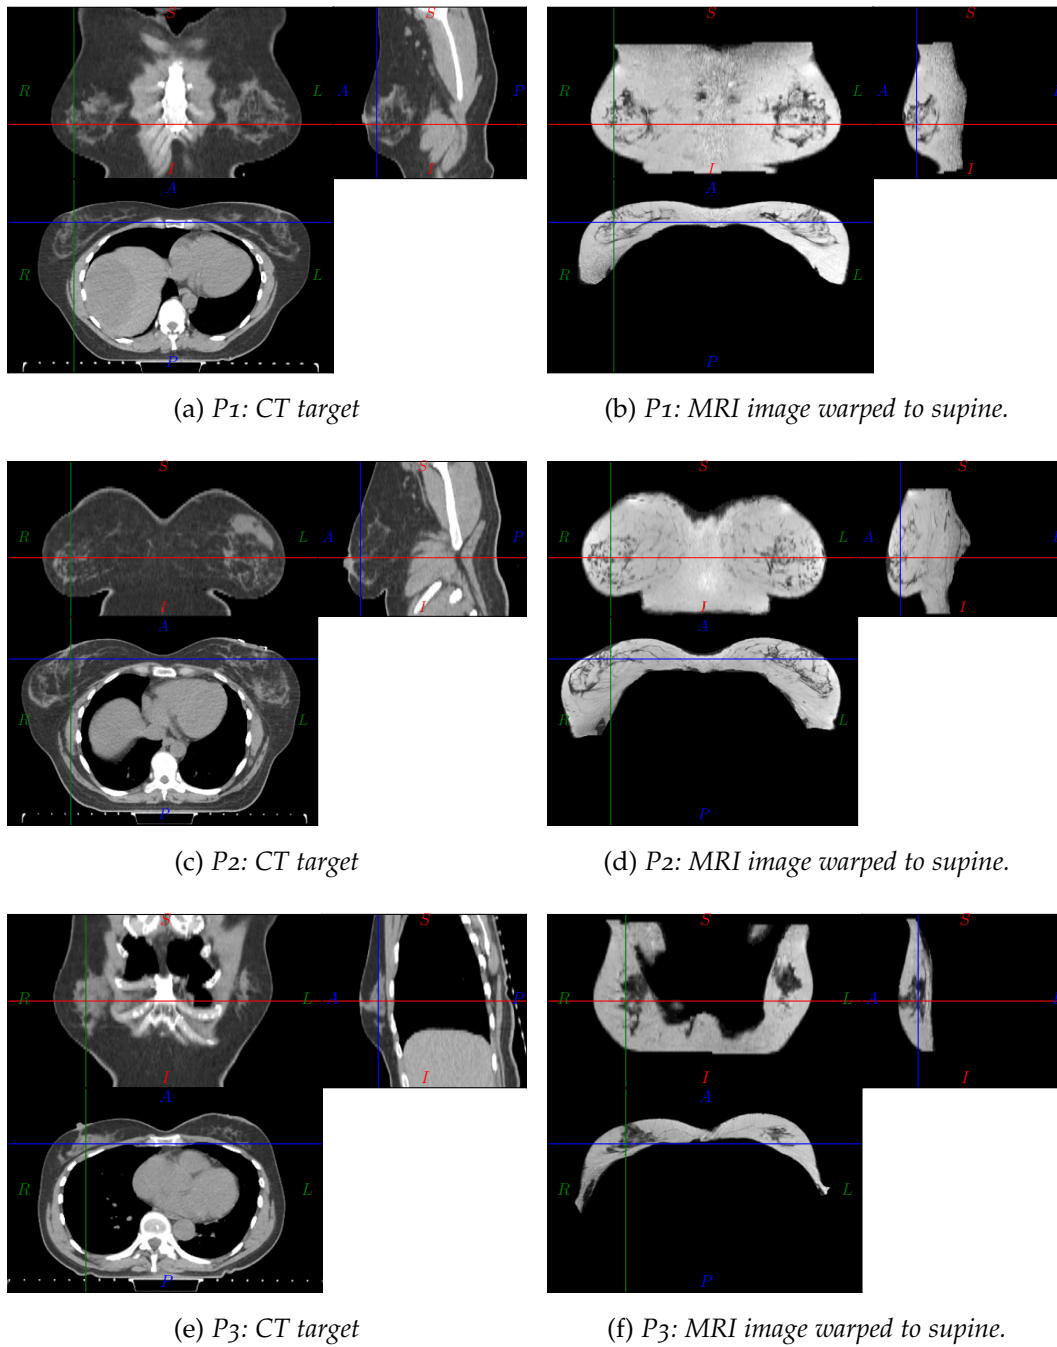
Pure surface driven registration result for all data sets. Breast conserving surgery was carried out on the left breast (right side on the image above) which causes morphological changes to the breast tissue between the MRI and the CT acquisition.
